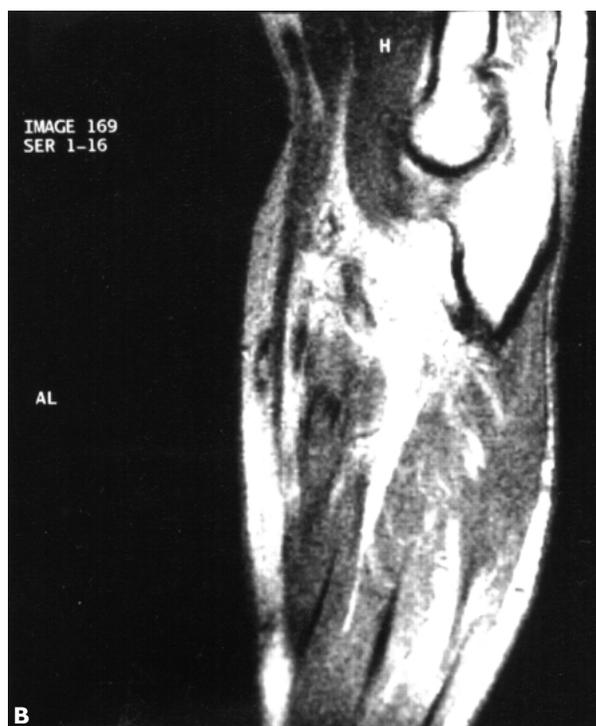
T₂-weighted magnetic resonance images of the case patient's right elbow. (A) Cross section. (B) Longitudinal section.
